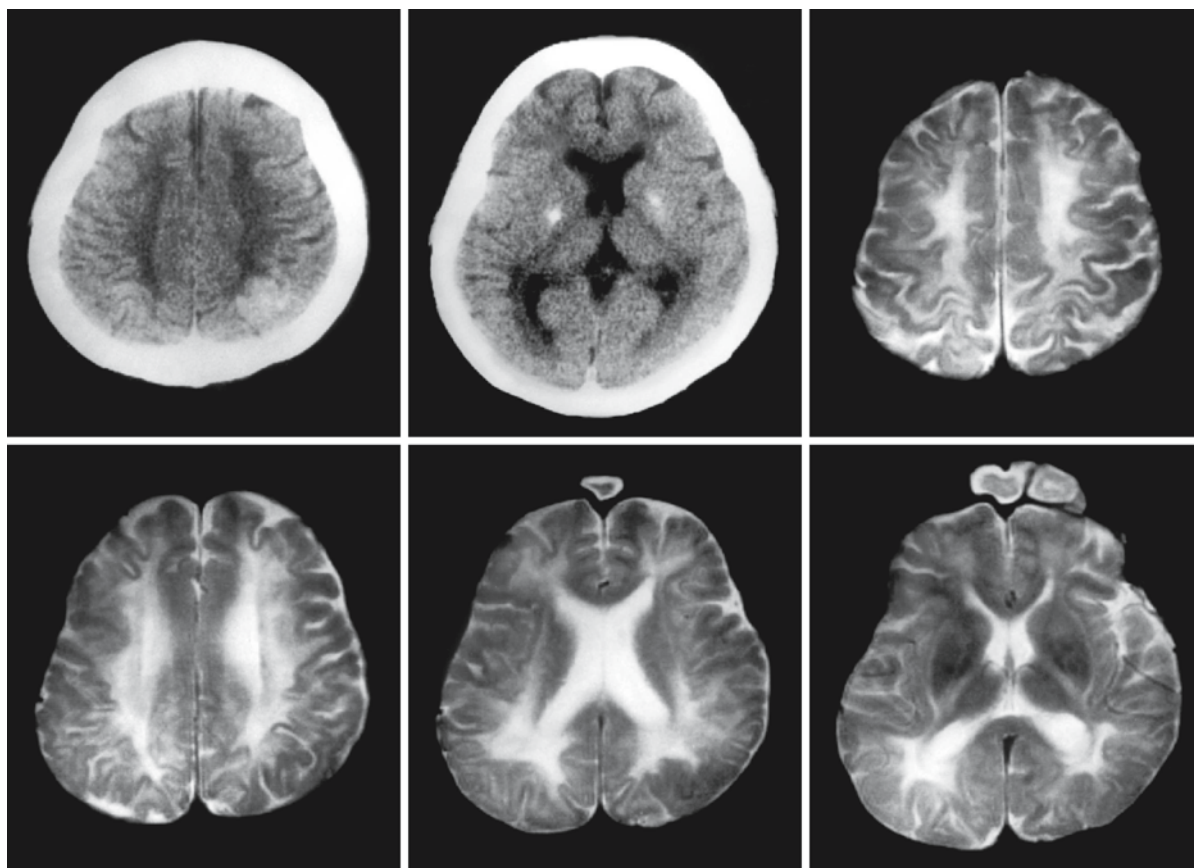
A 20-year-old male with dihydropteridine reductase deficiency. CT (*upper row, left and middle*) shows some calcification of the basal ganglia and the parietal corticosubcortical junction. The MRI shows diffuse abnormality of the white
